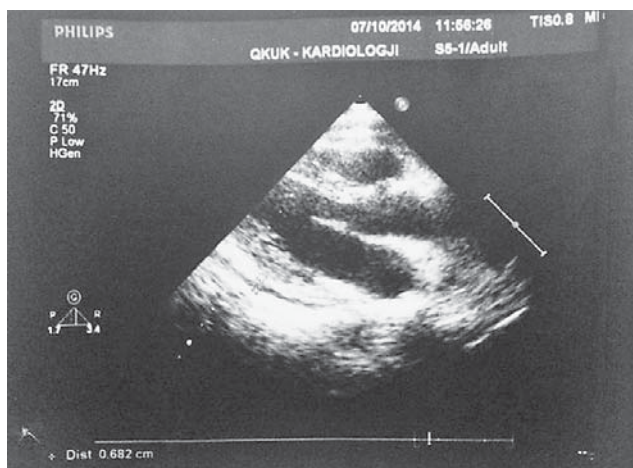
2D echocardiography showing pericardial effusion of approx. 6.8 mm on the posterior LV wall
